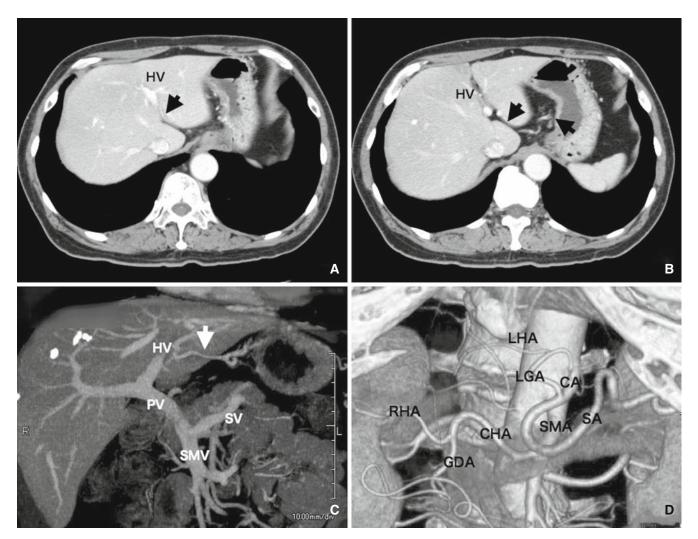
Multidetector computed tomography (MDCT) and three-dimensional computed tomographic angiography (3DCTA) imaging in case 31; arterial and venous variants were detected by MDCT (A and B), so 3DCTA was performed additionally (C and D). The left gastric vein (LGV; *arrow*) starts from the stomach (B) and ends in the hepatic vein (HV; A). The venous phase of the 3DCTA imaging showed that the LGV flowed into the HV (C). The arterial
